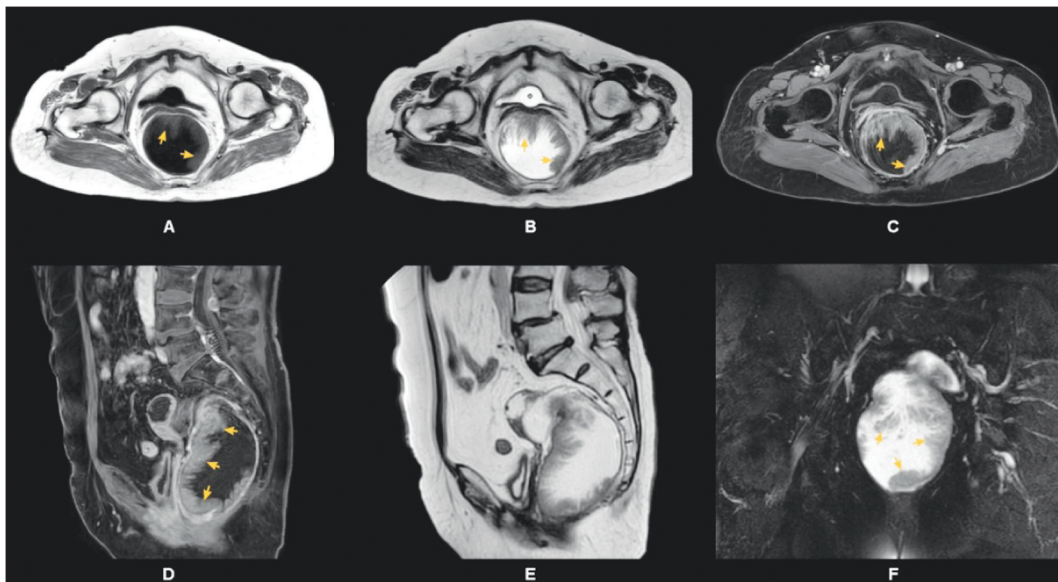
Contrast-enhanced pelvic magnetic resonance imaging demonstrates an intraluminal polypoid lesion (arrows) in the rectum without invasion in the mesorectal fatty tissue and fascia. (A) axial plan T1-WI; (B, E) axial and sagittal plan T2-WI; (C, D) axial and sagittal plan fat-saturated contrast-enhanced images; (F) coronal plan fat-saturated T2-WI. WI: Weighted imaging.
